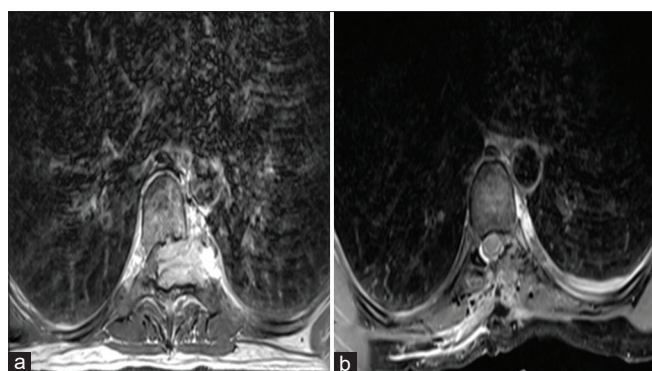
(a) Gadolinium-enhanced axial magnetic resonance image showing a brilliantly enhancing lesion at the T8 level that is extradural (black line forming the inner margin is the dura mater) with severe compression of the cord and preserved rib surface. (b) Gadolinium-enhanced axial magnetic resonance image taken on postoperative day 1 showing complete resection of the lesion with resolution of the compression on the spinal cord and preserved rib and pleural surface
